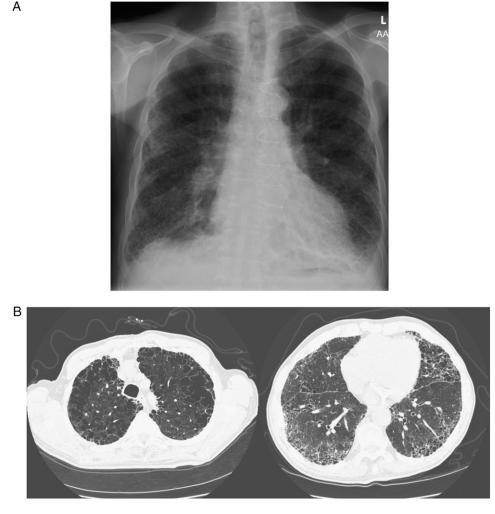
Images from a male smoker aged 77 years with combined pulmonary fibrosis and emphysema demonstrating upper-lobe emphysema and lower-lobe pulmonary fibrosis. A, Chest radiograph. B, CT image. Pulmonary function tests showed an FEV₁ of 108% predicted, FVC of 107% predicted, total lung capacity of 121%, and diffusing capacity of lung for carbon monoxide of 36% predicted. Echo-cardiography demonstrated grade I diastolic dysfunction and estimated pulmonary artery pressure of 30 to 40 mm Hg.
